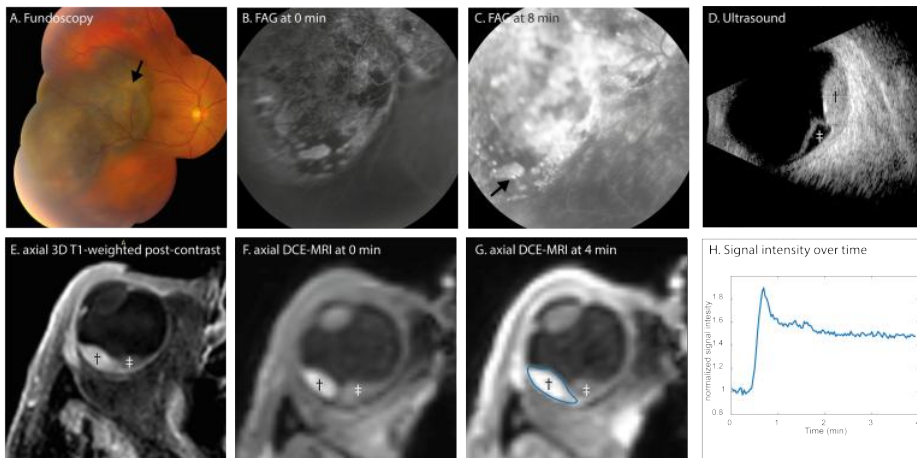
Conventional ophthalmic imaging and MRI of patient 13. (A–D) Conventional ophthalmic imaging of an UM. The fundus photo (A) shows a pigmented lesion with lipofuscin (arrow). The lesion is enhancing with pinpoints (C, arrow) on the fluorescent angiography (FAG, B, C). On ultrasound (US, D), the lesion (dagger) has an intermediate reflectivity, while the retinal detachment (double dagger) has a low reflectivity and the dimensions of the lesion are measured. On MRI, an enhancing lesion (dagger) with associated retinal detachment (double dagger) is visible (E–G). In contrast to the FAG, the change of the signal intensity after contrast administration can be visualized in DCE-MRI (H)
